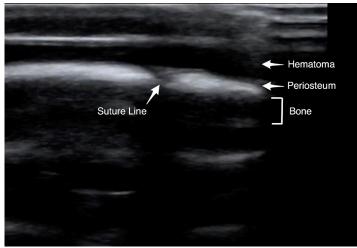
A point-of-care ultrasound demonstrating a normal cranium with an open suture line. An overlying hematoma is also identified.
